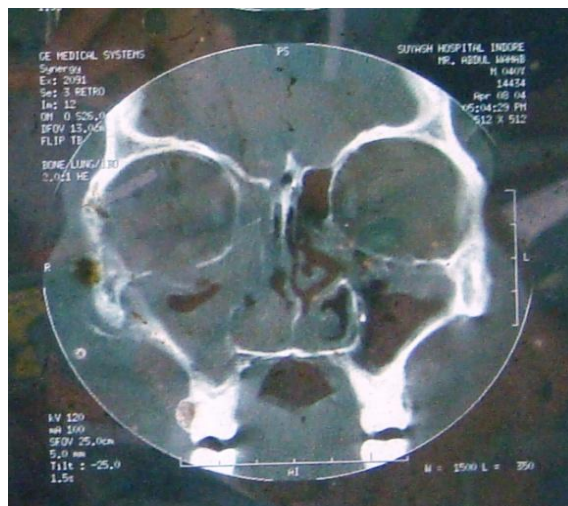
CT scan showing destruction of right infraorbital rim
